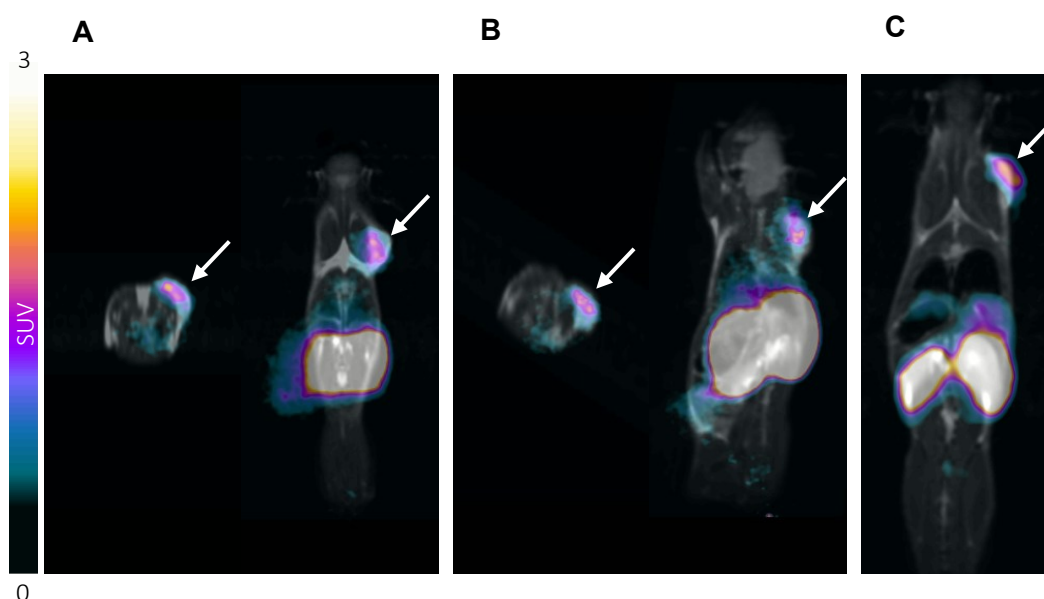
Preliminary PET/MRI images
